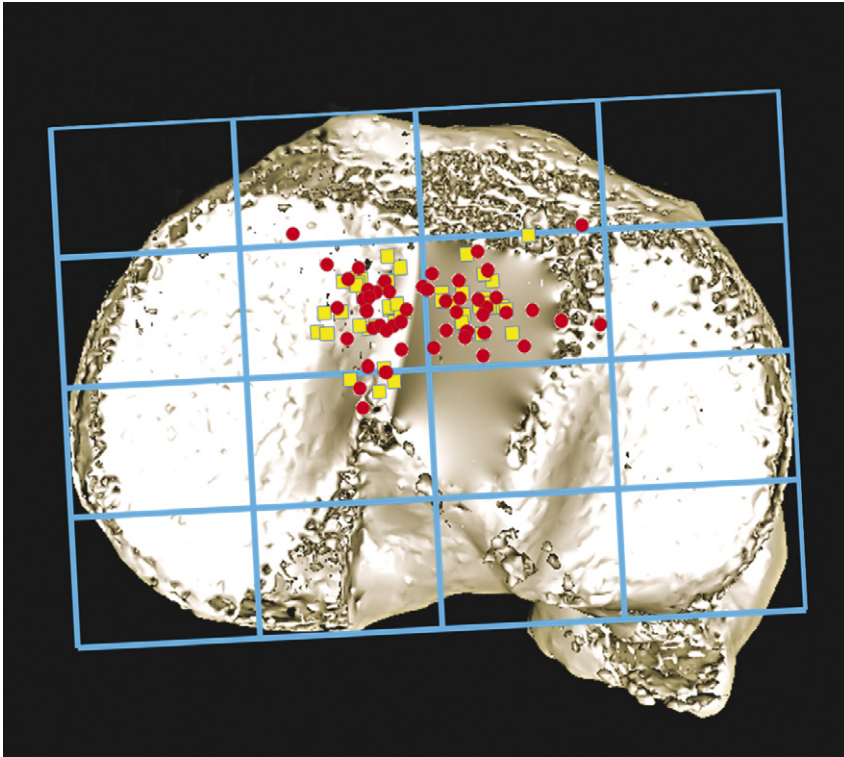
CAS(red dots) versus conventional(yellow squares) tibial intra-articular tunnel aperture position, projected for clarification on a cranial view of a fitted CT tibial plateau image of a randomly chosen right knee.
